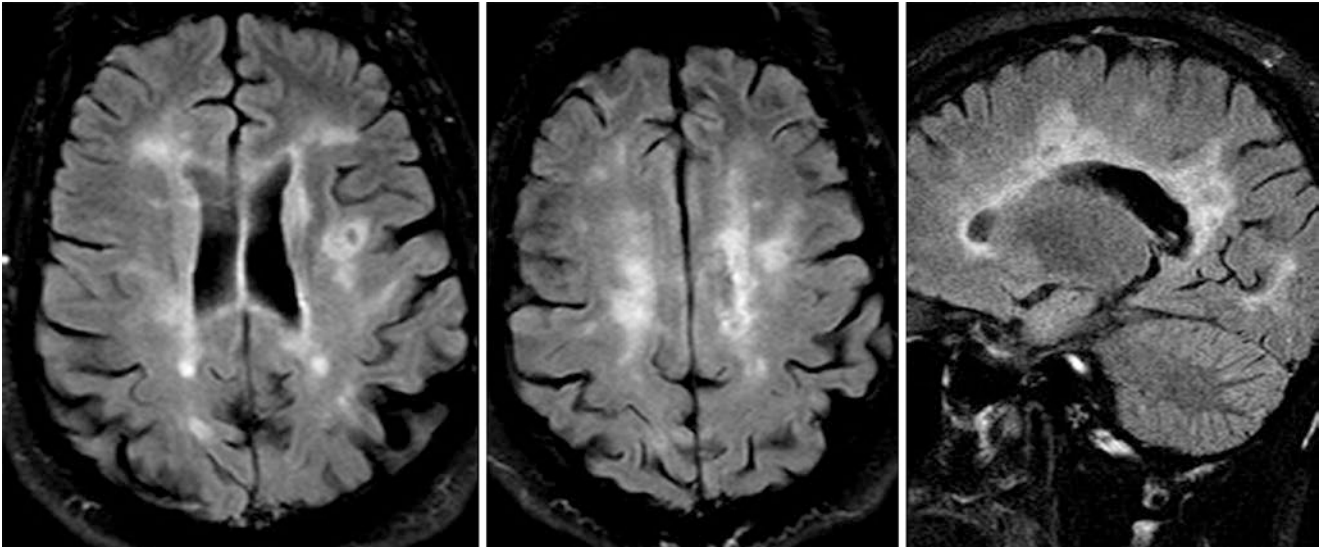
Comparison case of confluent lesions in multiple sclerosis (MS) in a 44-year-old with worsening symptoms. A 1.5 T MRI demonstrated confluent abnormalities throughout the PVWM on axial (*left and middle*) and sagittal (*right*) FLAIR images. Note the irregular PVWM lesions that are oriented perpendicular to the ventricles, typical of MS
